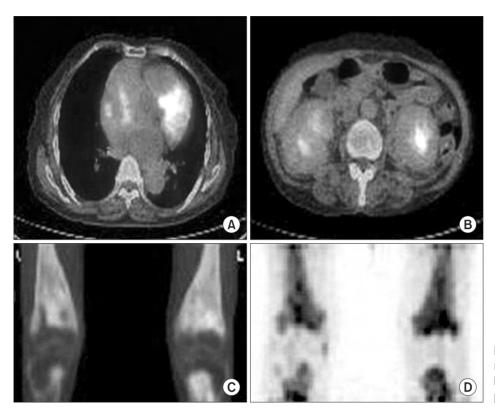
On PET CT, it showed high metabolic lesions of SUV 4.7 in heart (A), kidney (B), bilateral distal femoral, and proximal tibia (C, D).
